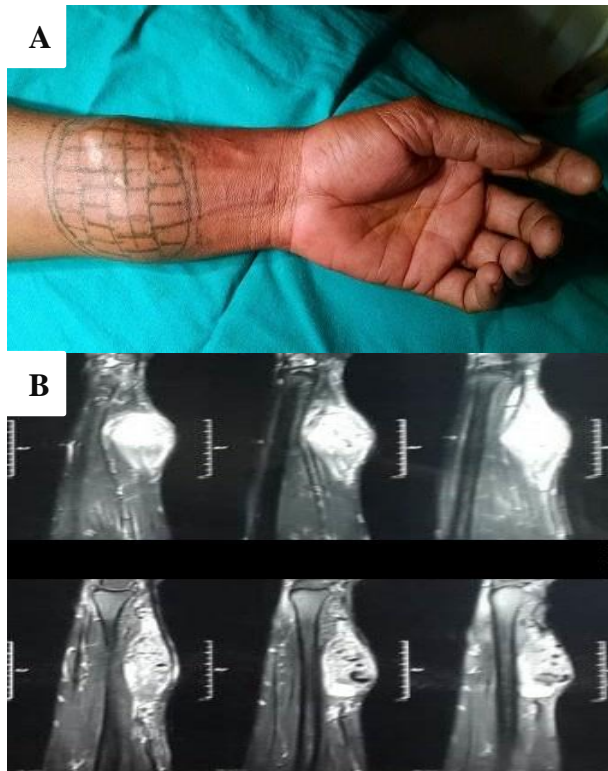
A & B: Left forearm high flow vascular malformation involving both radial and ulnar artery & FDS, MRI.
